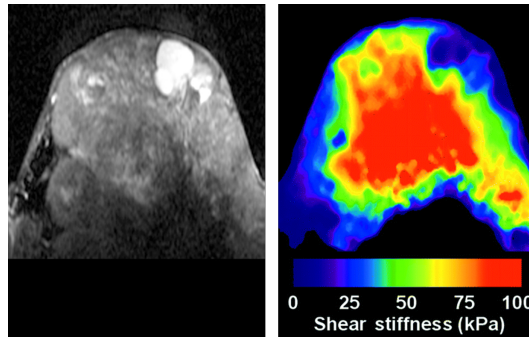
In vivo MRE on carcinoma patient. T2 MRI image is shown on the left and Elastogram map on the right, from [5].
